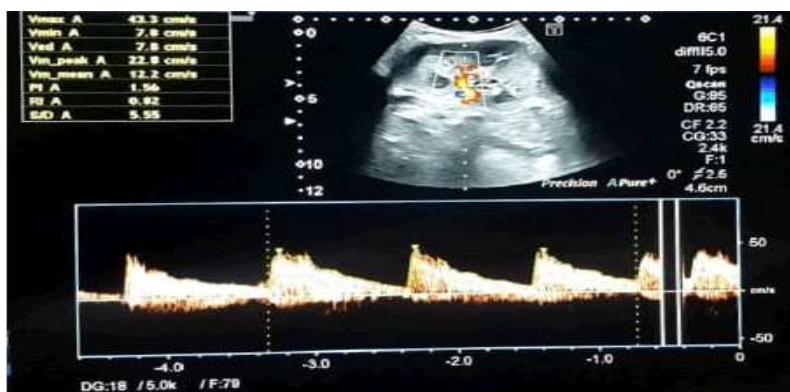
Doppler ultrasound image of a stage 4 chronic kidney disease with high resistive index of 0.82.
